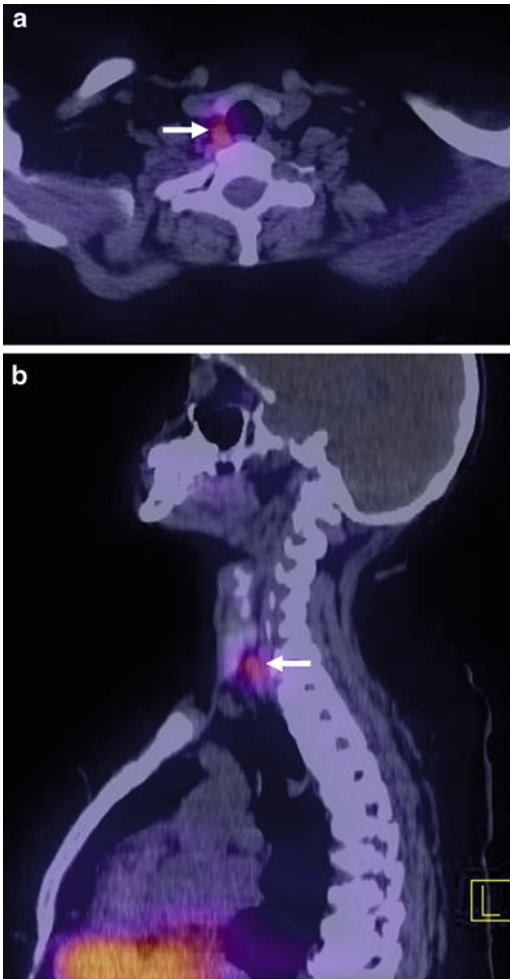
Ectopic parathyroid adenoma (*arrow*) in the right tracheoesophageal groove demonstrated on coregistered sestamibi SPECT/CT tomograms in the transverse (a) and sagittal (b) planes
